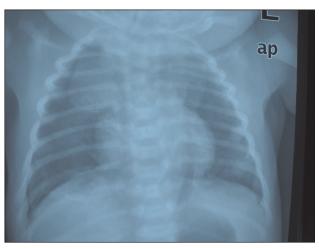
Chest x-ray showed a large-shadow large-shadow in the upper- right mediastinum.
